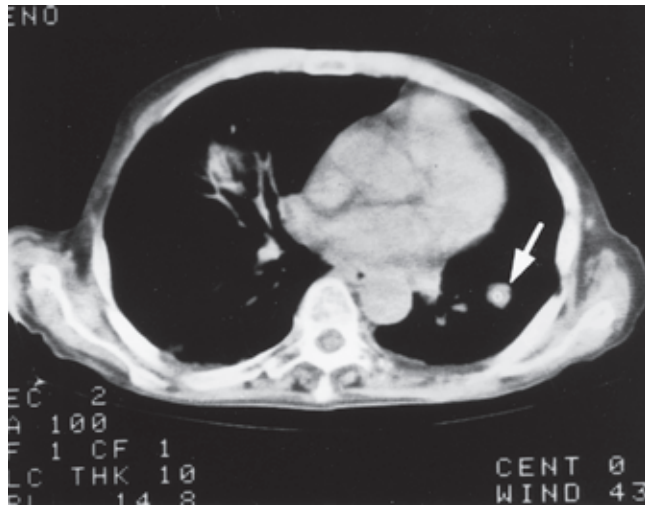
CT scan of chest. Mediastinum and heart appear white in the center of the scan, with less-dense lungs on either side. A lung tumor (*arrow*) appears as a white nodule in the lung.
